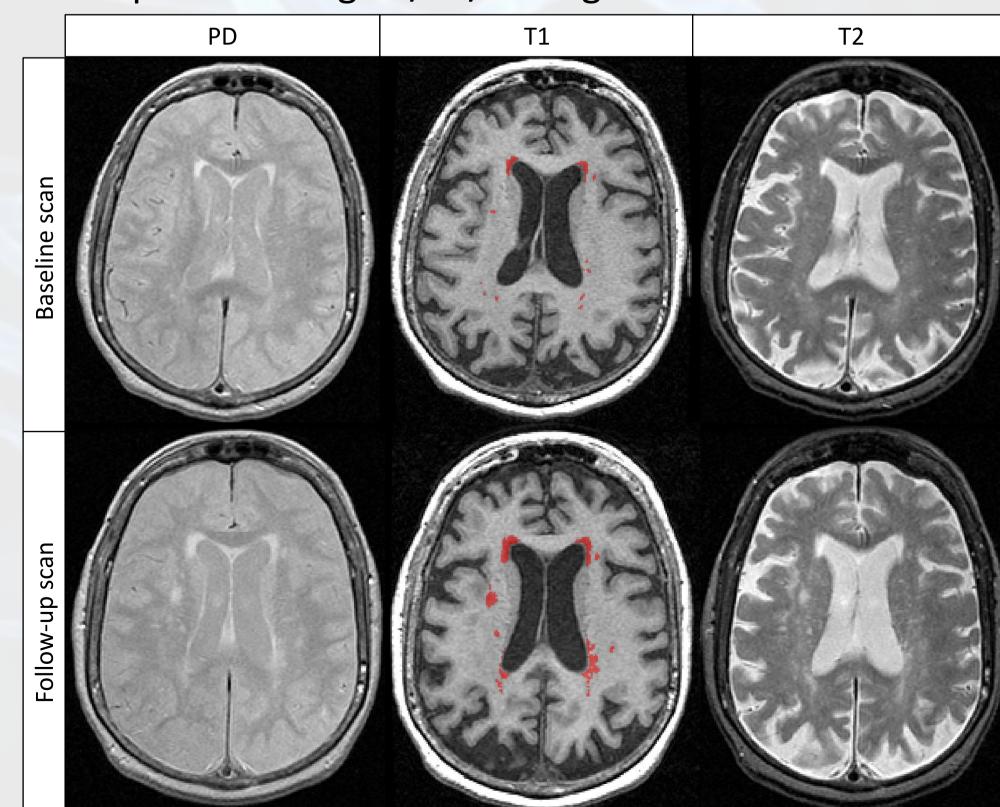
MRI scans showing longitudinal white matter progression. All images are from a single subject. LE WMH segmentation is shown in red on the T1-weighted images.
